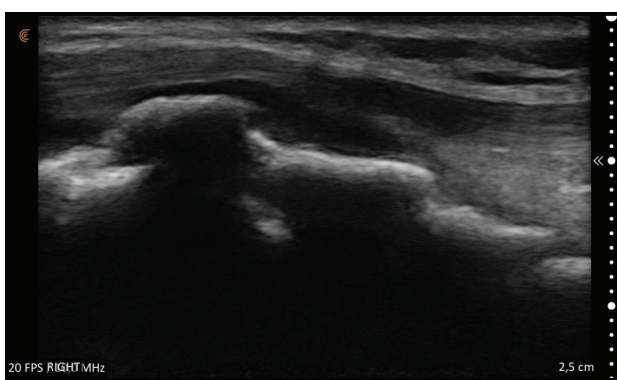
Ultrasound picture of further deformations of the right knee at the attachment point of the patellar tendon on the tuberositas tibiae.
